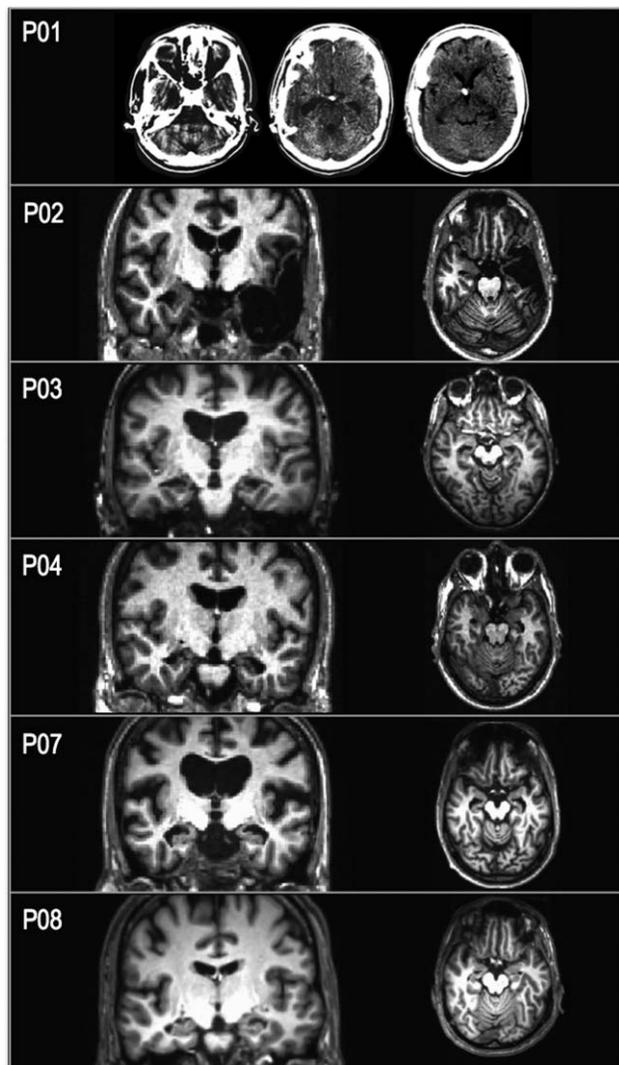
Structural CT and MRI scans, which depict medial temporal lobe (MTL) lesions for six of the eight amnesic patients (see Method). The left side of the brain is displayed on the right side of the image. CT slices show lesion location for P01 in the axial plane. T1-weighted MRI images depict lesions for P02, P03, P04, P07, and P08 in the coronal and axial plane.
